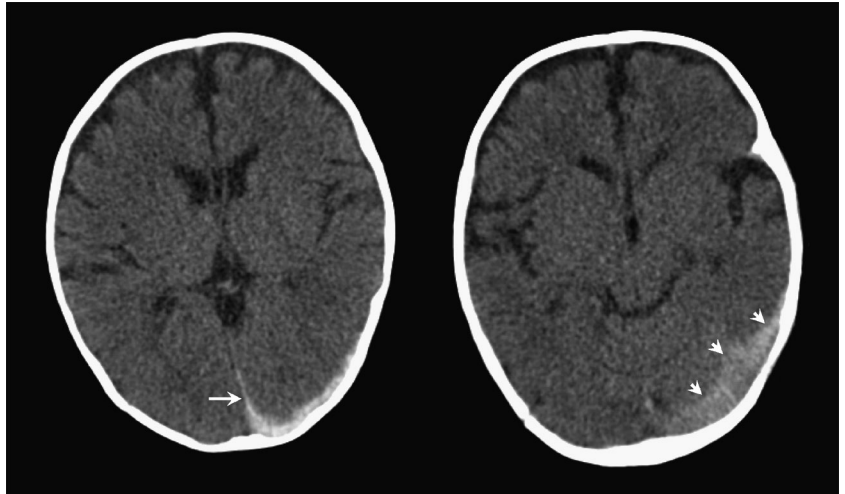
Images obtained from a 1-day-old female infant delivered by means of spontaneous vaginal delivery and with subsequent apneic episodes. Computed tomography demonstrates left-side temporal cerebral and extracerebral high-density hemorrhage (or thromboses); high-density hemorrhage is also demonstrated along the interhemispheric fissure, tentorium, and dural venous sinuses. The results of coagulopathy test and sepsis workup were negative (final diagnosis, birth trauma?).
